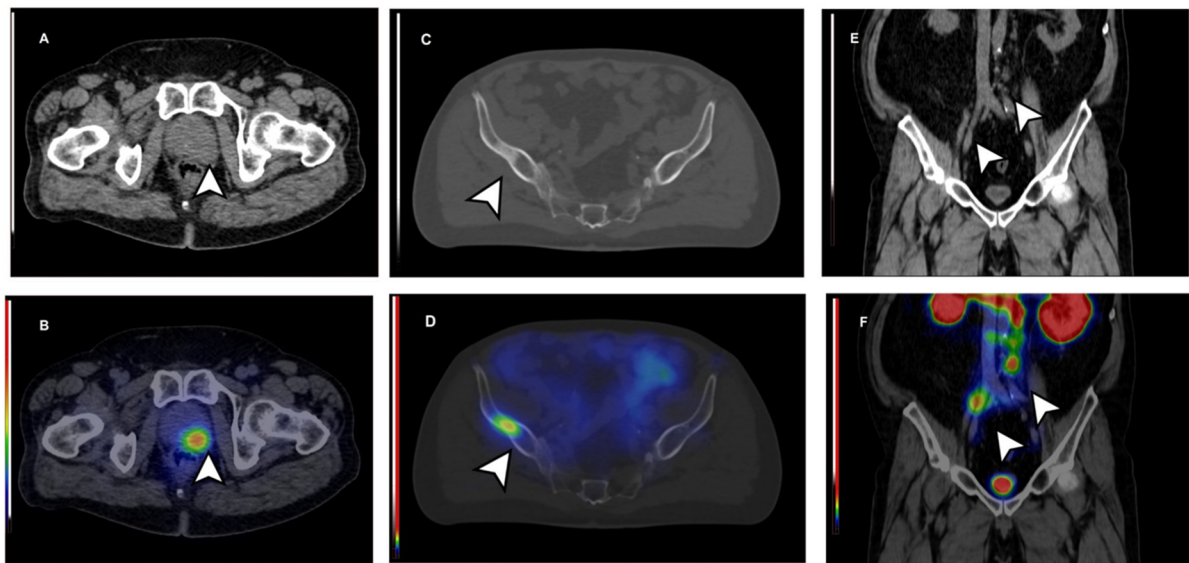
$^{99m}\text{Tc}$ -PSMA-I&S SPECT/CT in cancer patients. (A-B) Patient with primary prostate cancer tumor lesion with high TBR (TBR: 42, SUVmax: 22); (C-D) Patient with a bone metastasis with high TBR (TBR: 26, SUVmax: 12); (E-F) Patient with a lymph node metastases with similarly high TBR (TBR: 24, SUVmax: 8).
